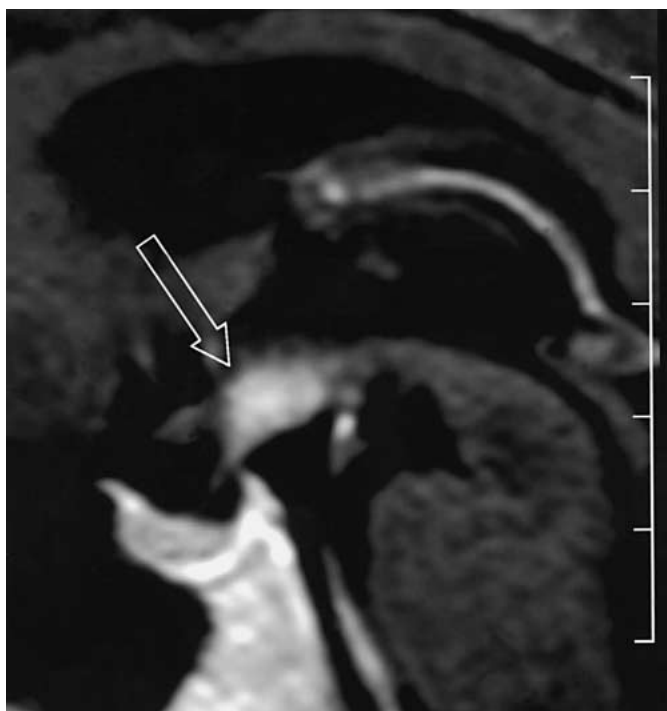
Cranial MRI (sagittal T₁-weighted image) showing the contrast-enhanced lesion in the posterior hypothalamus on first admission (arrow).
